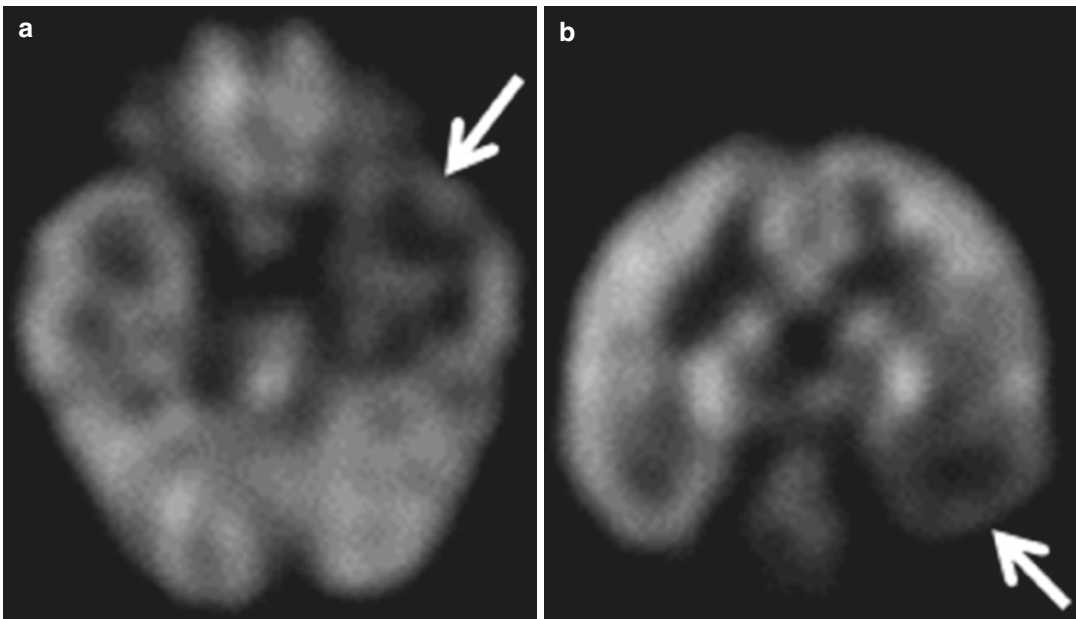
This 22 year old with history of medically refractory recurrent episodes of seizures had undergone FDG-PET scan of the brain. Transaxial (a) and coronal (b) images demonstrate hypometabolism in the left
